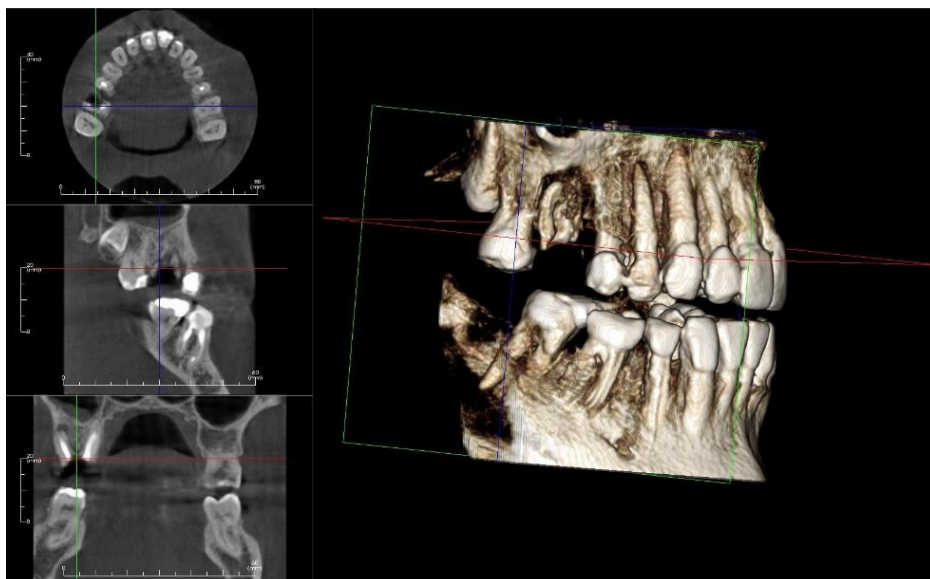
CBCT images showing adequate healing in the mesiobuccal socket.
